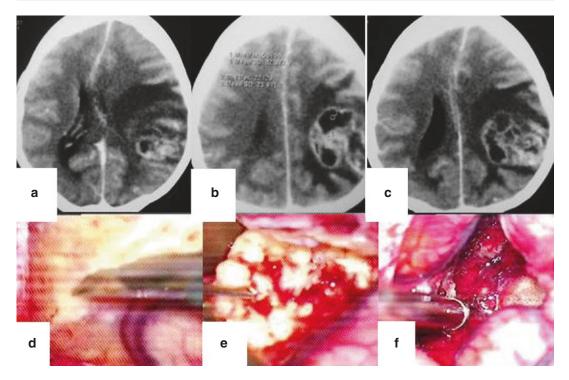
Contrast CT scan of the brain; (a–c) axial images showing left frontoparietal TB mass with edema and ventricular effacement. (d–f) Per-operative images showing different steps of excision of the TB lesion
